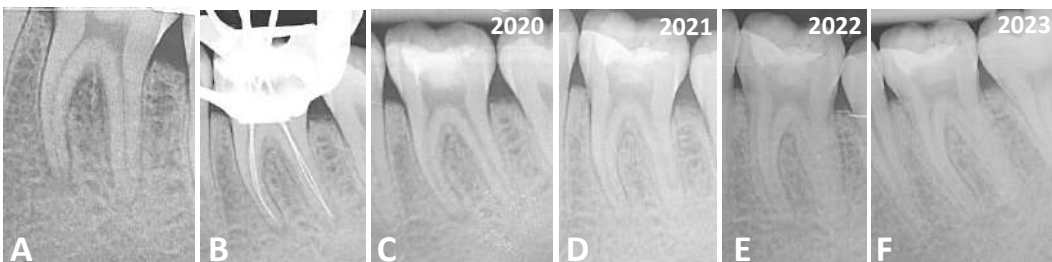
Pre and postoperative x-ray images (A and C). Determination of working length (B). Recall follow-up images at 12 months (D), 24 months (E), 57 month(F). A resolution of the periapical lesion and sclerosis of the root canals (C-F) indicating a successful revitalization.
